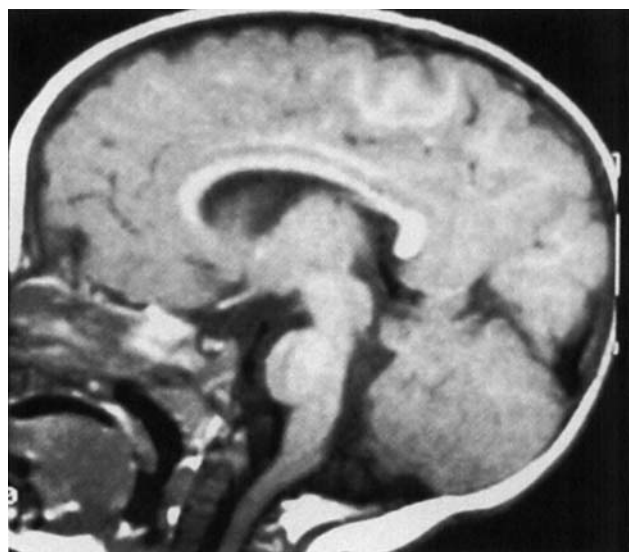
Magnetic resonance imaging scan from patient 2. The cerebellar vermis is absent. Prepontine and basilar cisterns are large. The fourth ventricle is displaced but there is no hydrocephalus. The aqueduct is normal.
